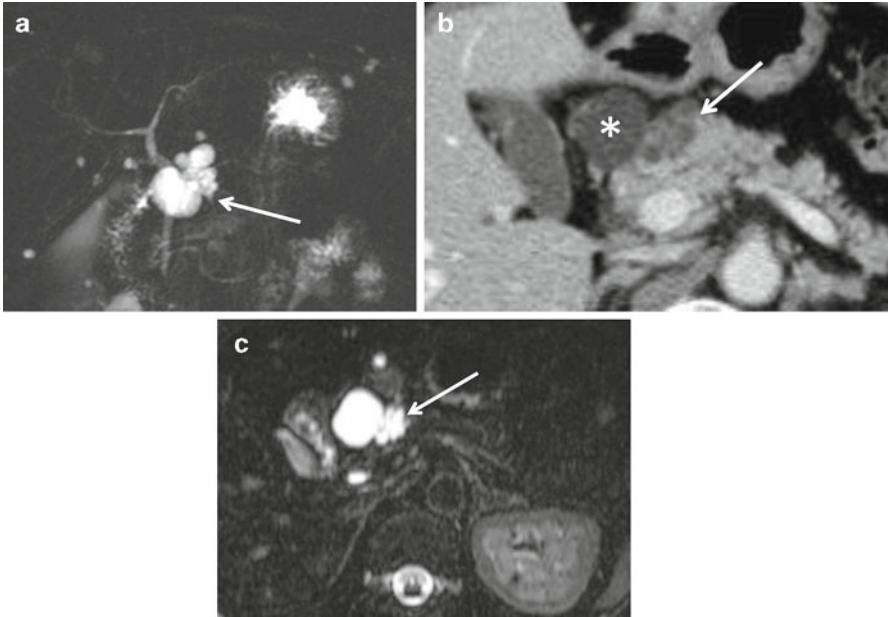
Mixed-type serous cystic neoplasm (mixed microcystic and macrocystic SCN). (a) Thick slab 2D-MRCP demonstrates a lobulated multilocular cystic mass in the pancreatic head (*arrow*). (b) The portal venous phase of axial MDCT shows thin-walled macrocyst (*asterisk*) and cluster of microcysts (*arrow*). (c) Axial thin slab MRCP more clearly shows a cluster of microcysts (*honey-comb pattern, arrow*). MRI better characterizes this cystic lesion than MDCT
